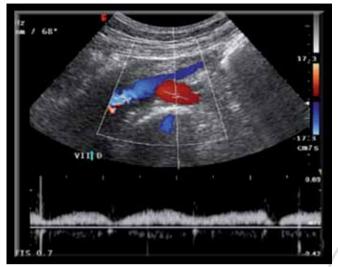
Abdominal transparietal duplex ultrasound (iliac vein compression syndrome). Compression of common right iliac vein with an increase in flow direction right/left internal iliac vein due to collaterals among the left to the right axis.
